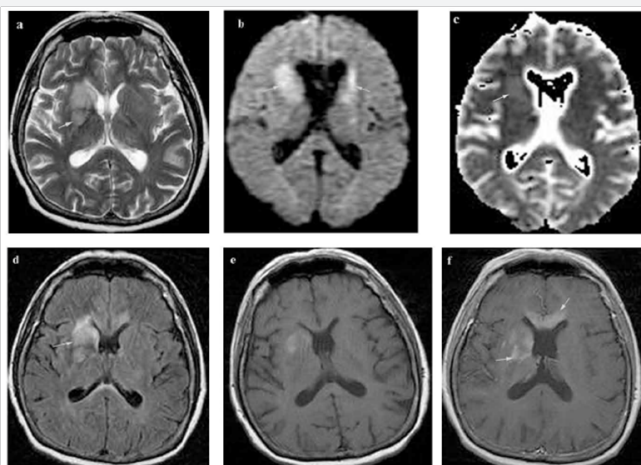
(a,b,c,d,e,f): MRI (November 28, 2012). Moderate regression of the hyperintensities areas in T2 w (a), diffusion (b) ADC map (c) and Flair involving the genu of corpus callosum, and the lenticulo-caudate regions predominantly on the right side. Persistent T1 w hyperintense area in the right lenticulo-caudate region (e), Contrast enhancement of the lesions involving the genu of corpus callosum and the right lenticulo-caudate region (f).
